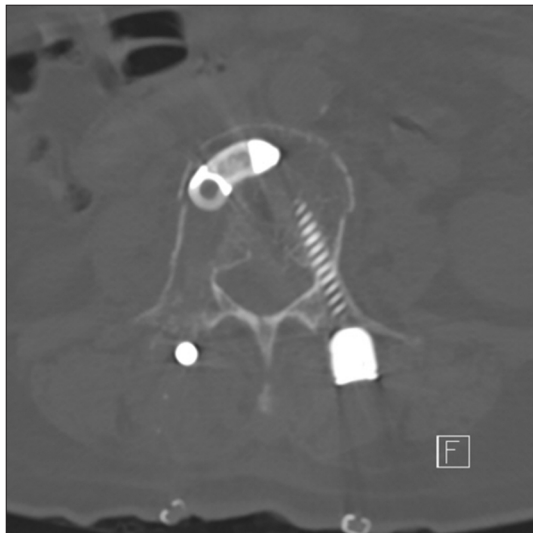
Postoperative axial computed tomography image showing an intact medial wall of the pedicle after cage insertion.
